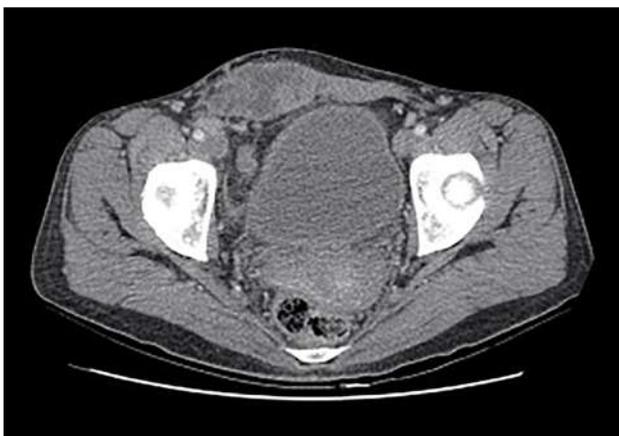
Computed tomography scan of the abdomen and pelvis (portal phase) showing an expansive process in the anterior abdominal wall and pelvis and lymph node enlargement in the external and inguinal iliac chains.
